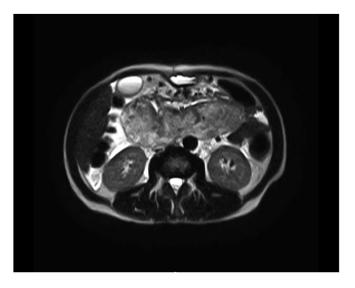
MRI without contrast showing an obstructing intramural duodenal hematoma.
